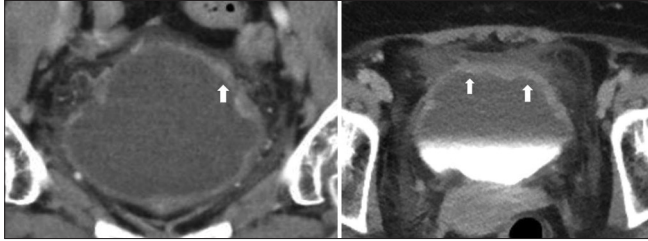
The computed tomography of the urinary bladder in a woman with Hunner's lesion showing diffuse thickening of the bladder wall (arrows). The thickened portions of the bladder wall are compatible with the Hunner's lesions appears in cystoscopy
